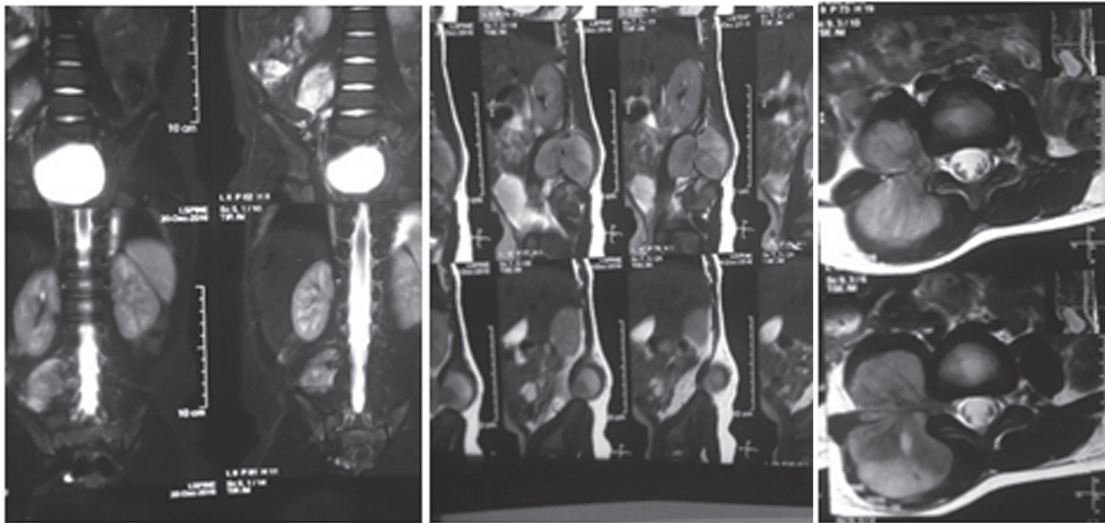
1a. MRI of spine T2W2 coronal image showing isointense mass in the right lumbar region. 1b. MRI of spine T2W2 sagittal images showing para vertebral mass over the lumbar sacral region. 1c. MRI of Spine T2W2 axial image showing isointense para vertebral mass with intracanalicular extension.
